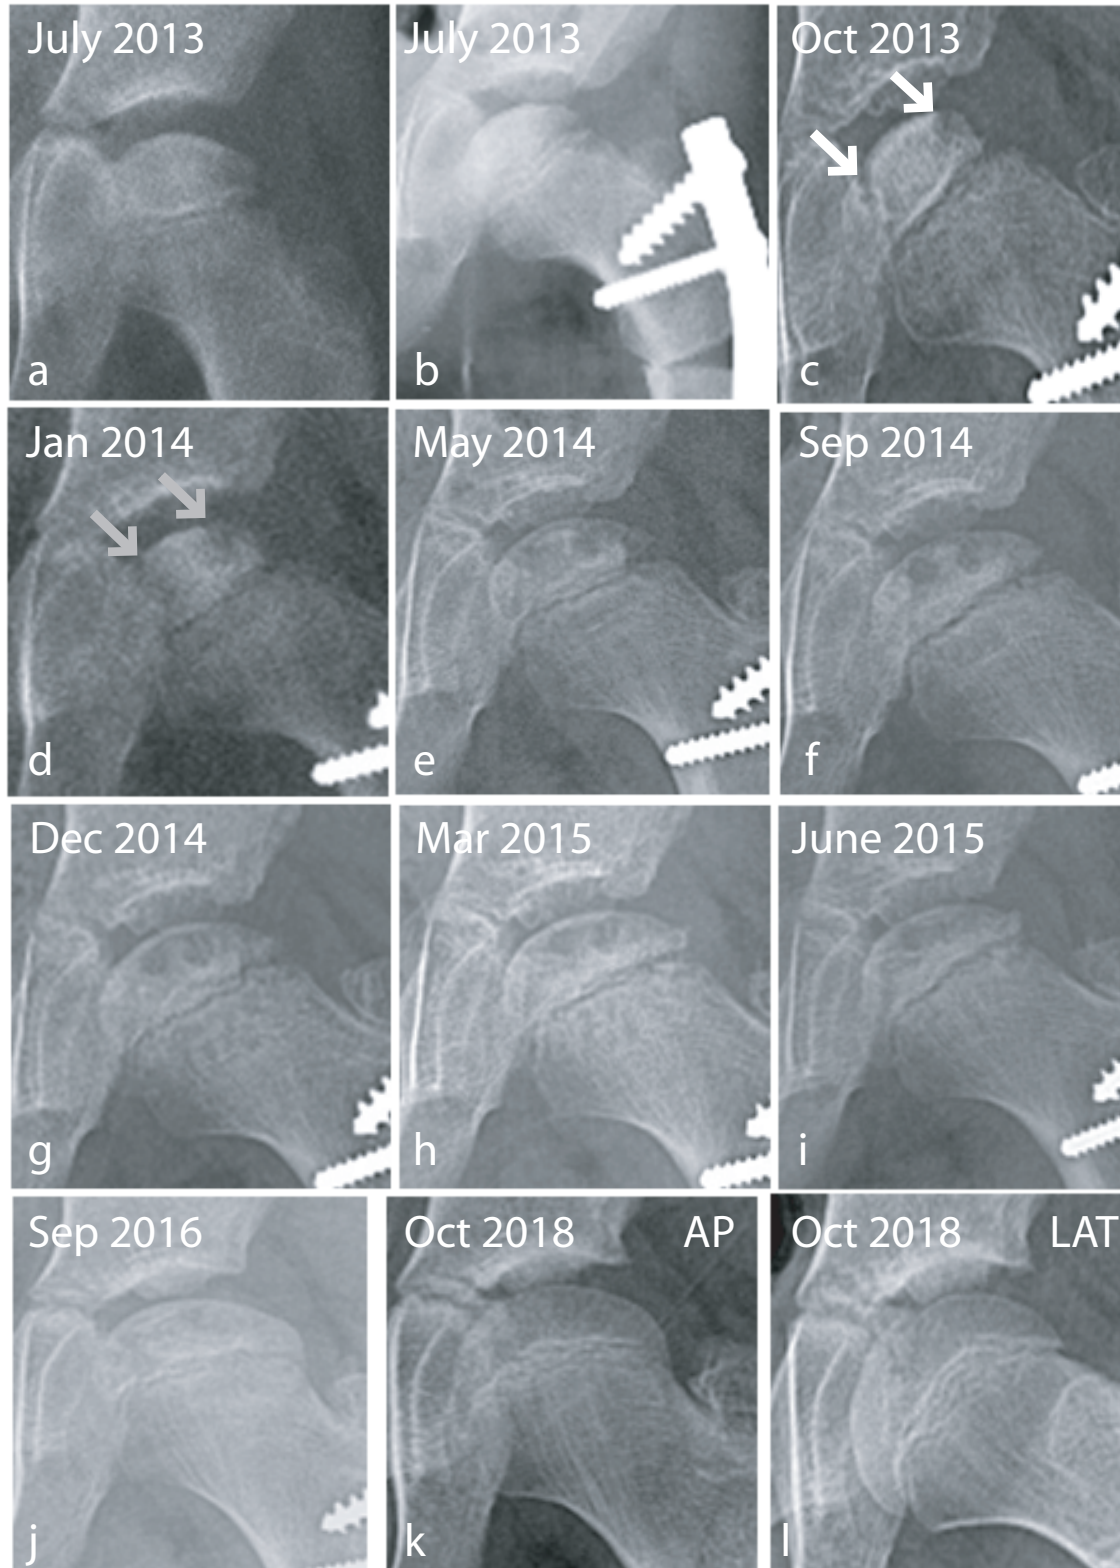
Sequential radiographs of a child who underwent proximal varus femoral osteotomy in Stage Ib of the disease from presentation (a-l) showing the pattern of evolution of the disease. In this patient early fragmentation begins (c; white arrows). Within three months the fragmentation fissures are less clearly defined (d; grey arrows). Four months later there is no progression of fragmentation (i.e. the disease has not passed through stage IIb). The fissures of early fragmentation are also not seen. The final outcome was excellent with a spherical femoral head (k, l). This pattern of evolution is the abortive fragmentation pattern.
